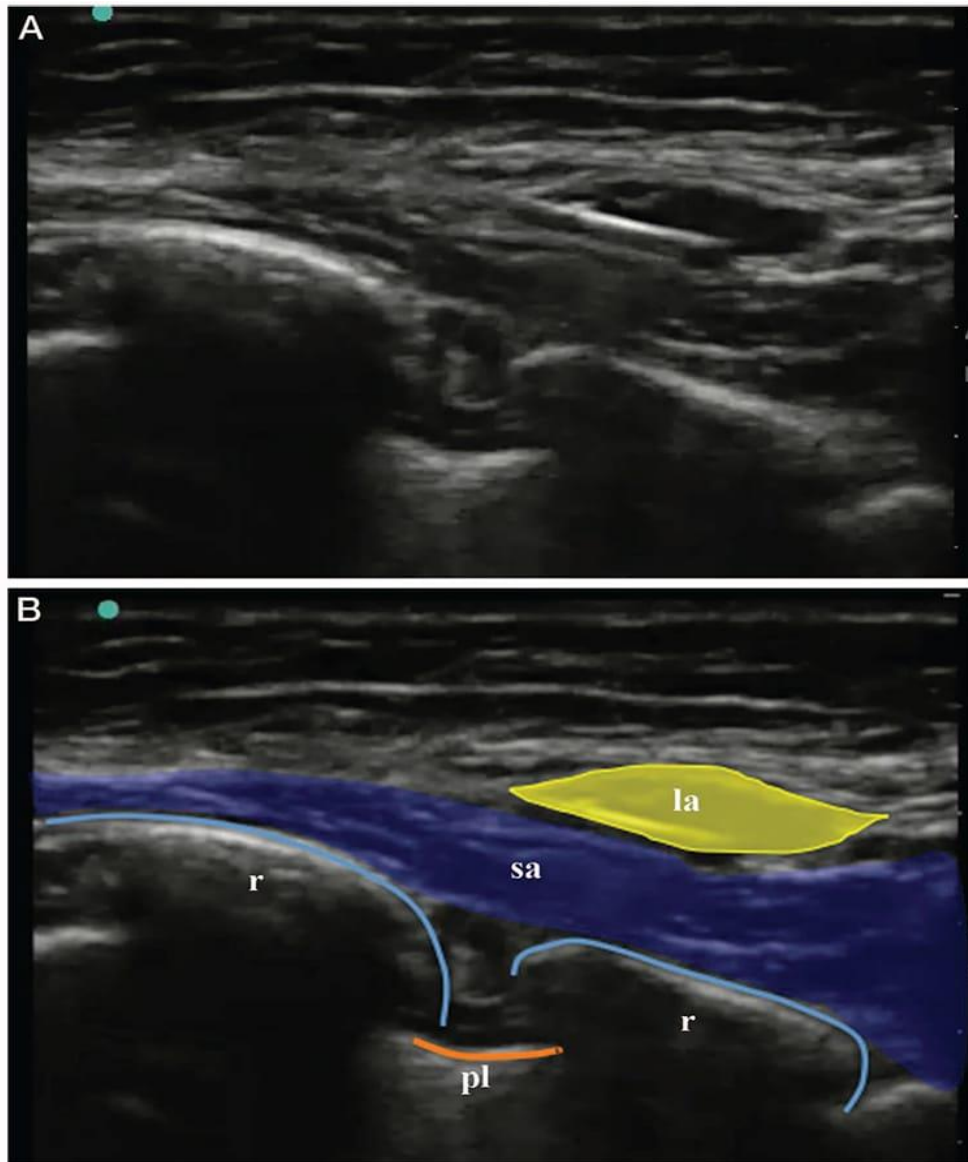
Ultrasound images showing the distension and the opening up of the fascial plane between the serratus anterior and the latissimus dorsi muscles subsequent to the injection of local anaesthetic. la, local anaesthetic; pl, pleura; r, rib; sa, serratus anterior. [21].
